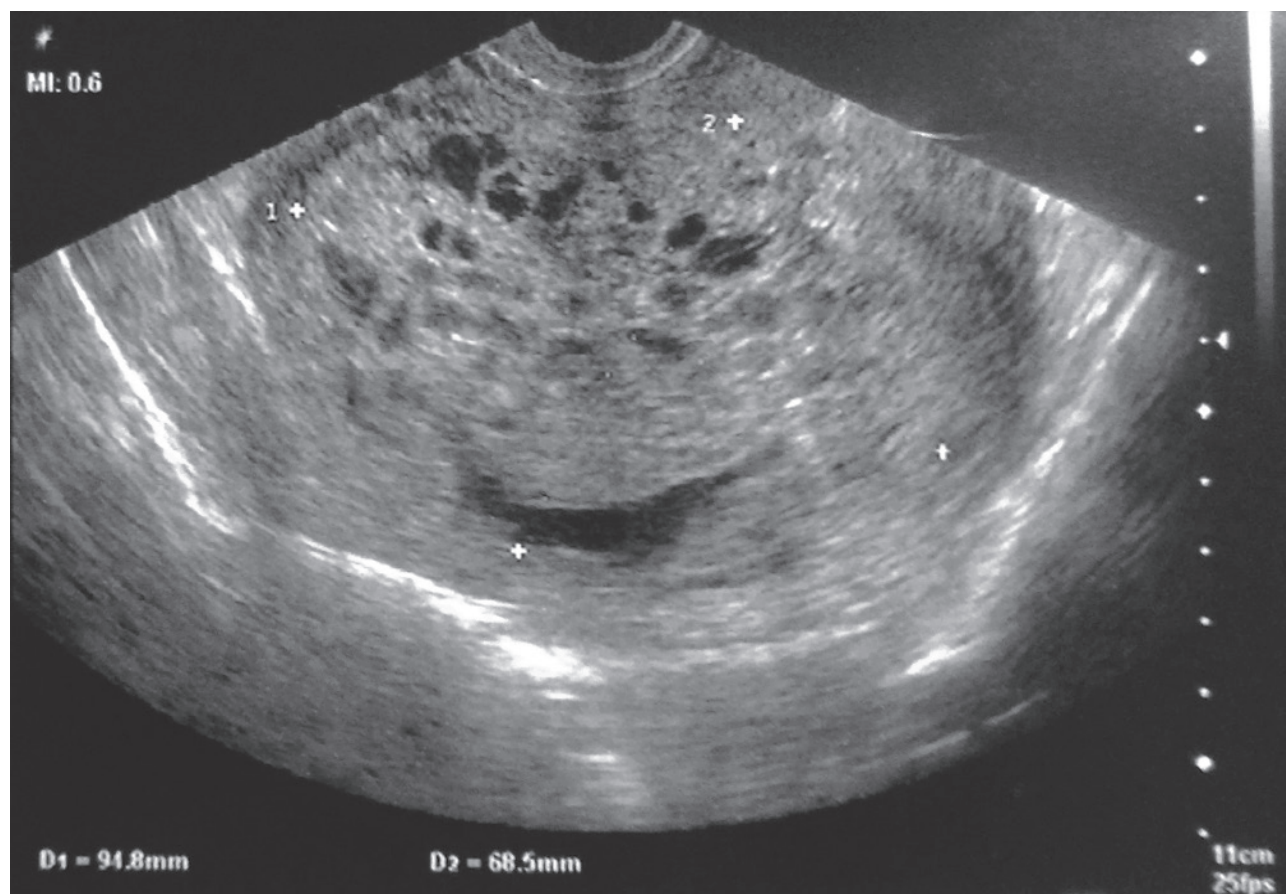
Ultrasonography revealing the typical bunch of grapes sign
